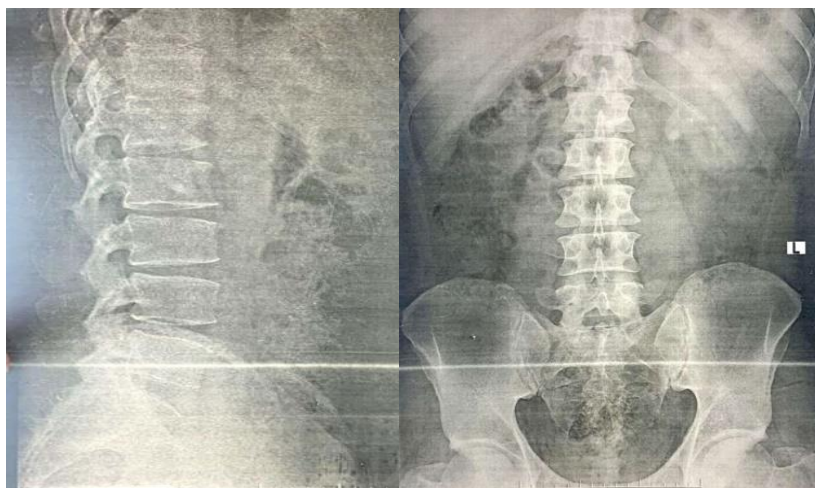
Preoperative plain x-ray AP and lateral views of lumbosacral spine.
